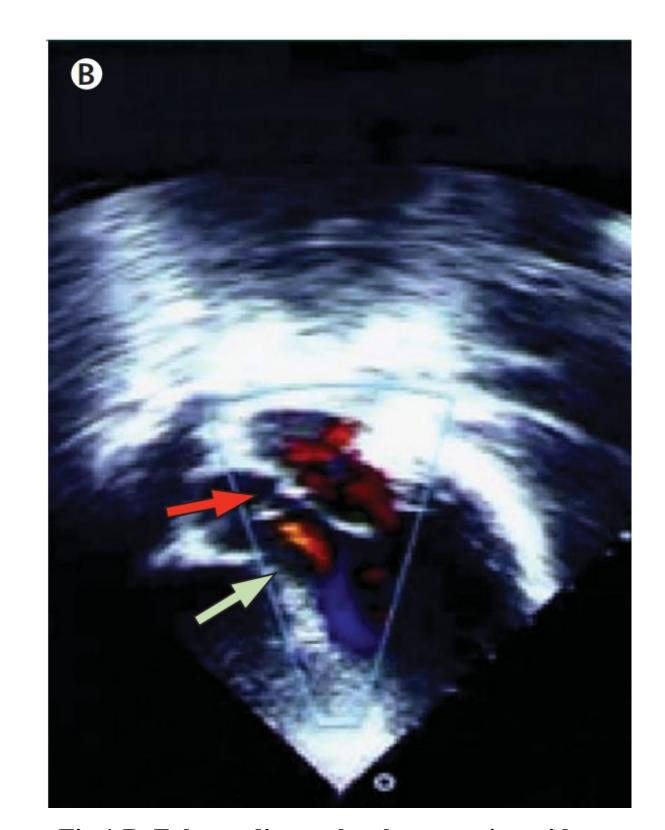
B. Echocardiography shows a tricuspid aortic valve with a thickened right cusp (red arrow) and mild aortic regurgitation (green arrow)
